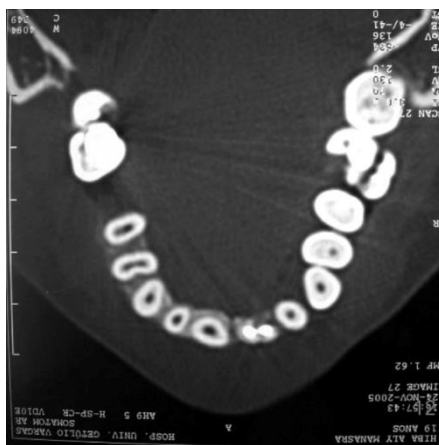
CT examination; transversal
